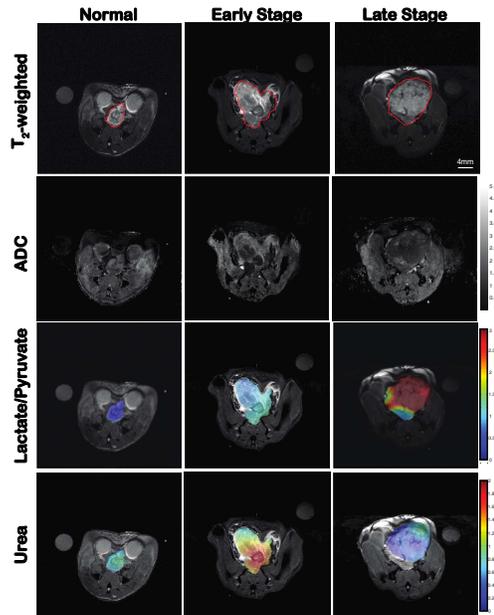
Representative T₂-weighted MR images, ADC maps, ratio maps of [1-¹³C]lactate to [1-¹³C]pyruvate and hyperpolarized ¹³C-Urea distribution in normal prostate, early and late stage TRAMP tumor.
